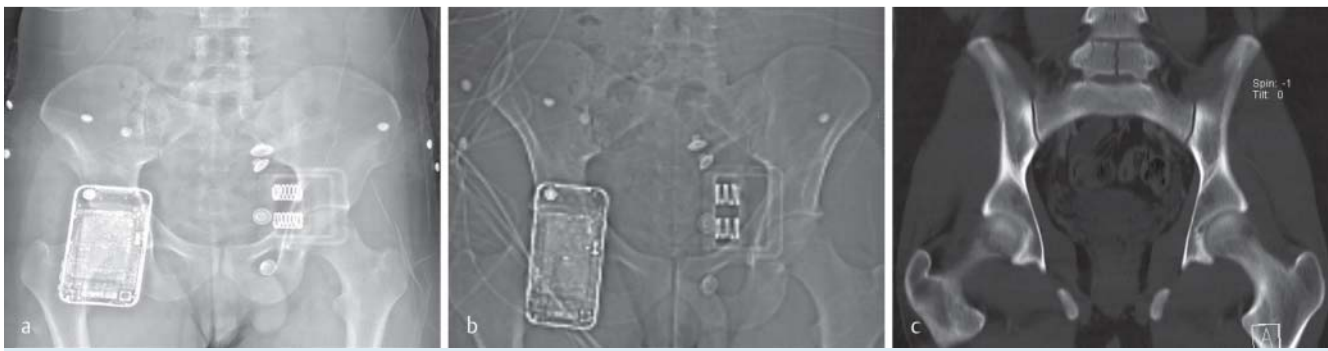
23-year-old man who was involved in a motor vehicle accident. In LS a and CT topogram b the split fracture of the 5th lumbar vertebra is not visible. The coronal reformation c of the MSCT data clearly shows the fracture.
